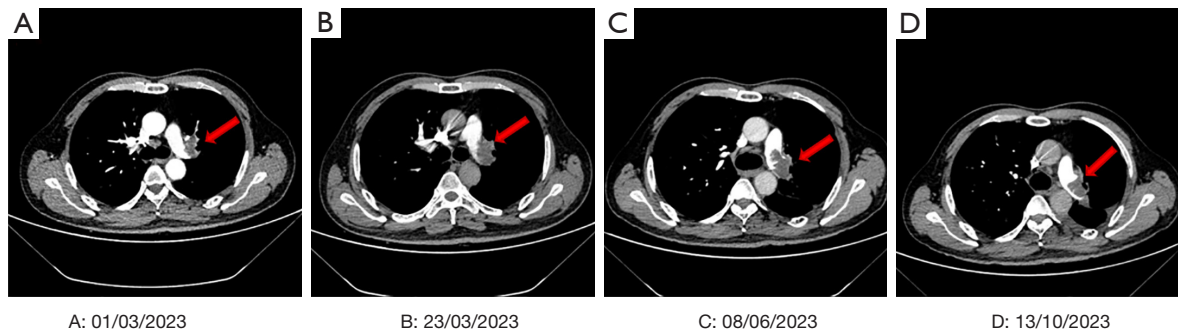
CTA pulmonary angiography of patient. (A) CTA shows a nodular filling defect in the main trunk of the left pulmonary artery. (B,C) The filling defect is still visible in the main trunk of the left pulmonary artery, which has progressed from the previous one. (D) The filling defect shadow in the trunk of the left pulmonary aorta has narrowed and improved from the previous one. The left pulmonary aortic trunk has a better filling defect shadow than the previous one. Red arrows indicate the location of the thrombus. CTA, computed tomography angiography.
